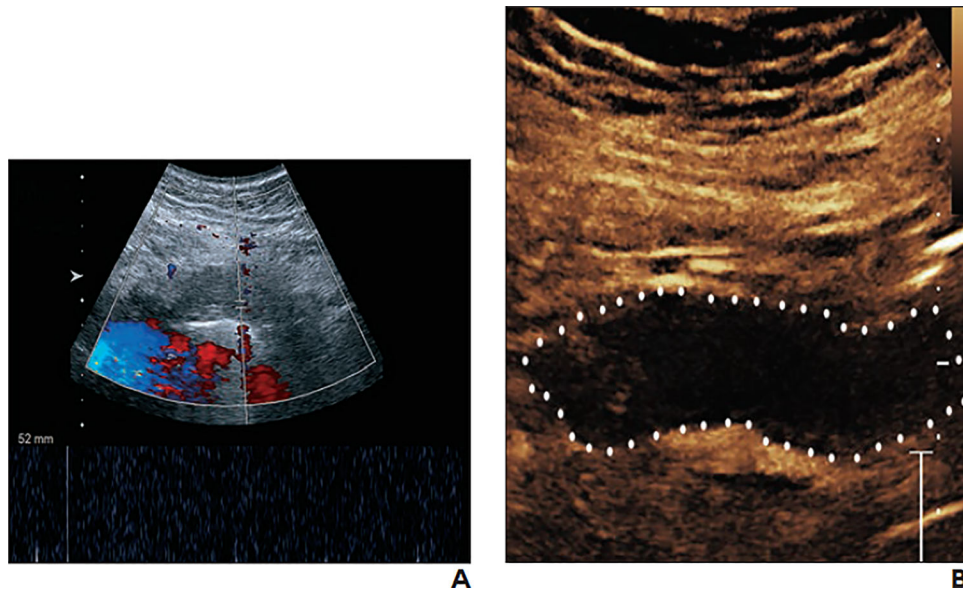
39-year-old woman with pancreas graft arterial thrombus found at surgery. Concordant results were found on Doppler ultrasound and contrast-enhanced ultrasound images. A, Doppler ultrasound image was interpreted by reader as lacking definite color signal, and spectral waveforms were either absent or severely diminished. B, Contrast-enhanced ultrasound image was interpreted by reader as showing no contrast signal throughout graft (area within *dotted outline*)
